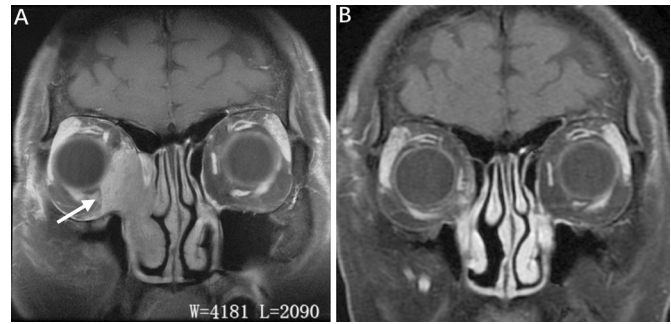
Coronal MRI A: A homogeneous soft tissue mass involving the lacrimal sac and nasolacrimal duct, extending to the right ethmoid sinus *via* lamina papyracea (white arrow). The medial rectus muscle, inferior oblique muscles and portions of the orbital fat were also involved. B: Almost complete resolution of the lesion one year after treatment (surgical resection and oral glucocorticoid). MRI: Magnetic resonance imaging.
